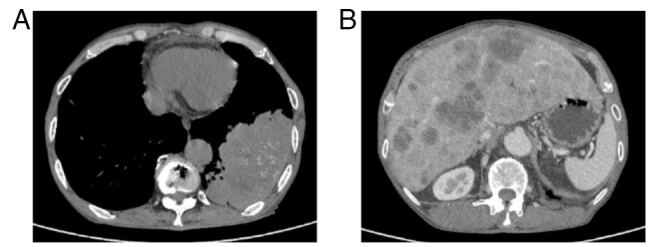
(A) Computed tomography scans showing a 12.3-cm lung lump in the left lower lobe. (B) CT of the liver after contrast enhancement showing numerous liver metastases.
